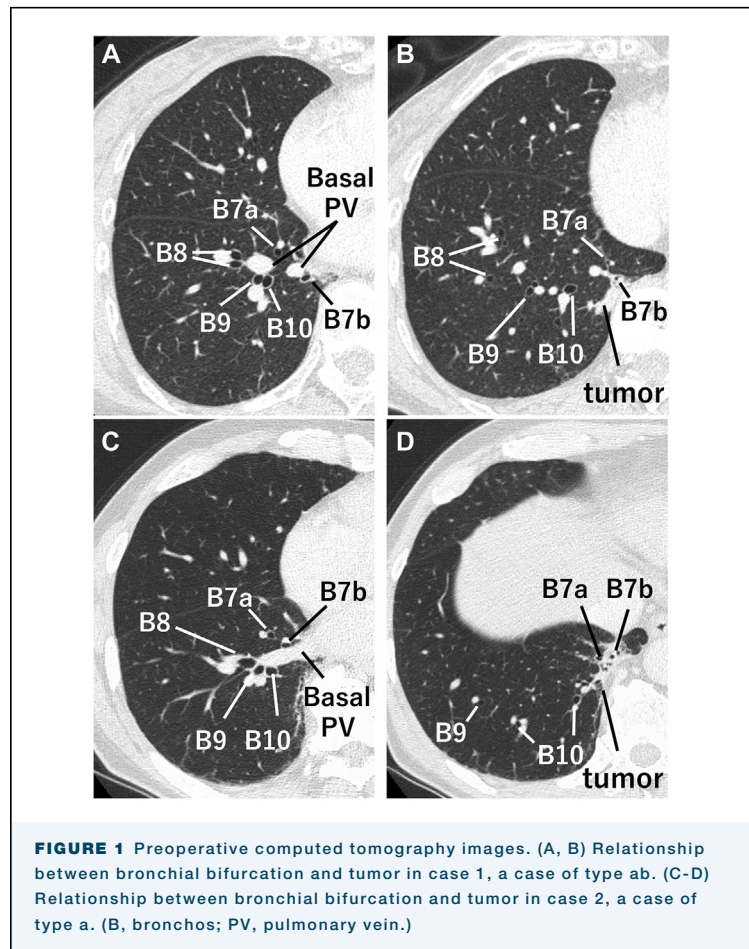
Preoperative computed tomography images. (A, B) Relationship between bronchial bifurcation and tumor in case 1, a case of type ab. (C-D) Relationship between bronchial bifurcation and tumor in case 2, a case of type a. (B, bronchos; PV, pulmonary vein.)
